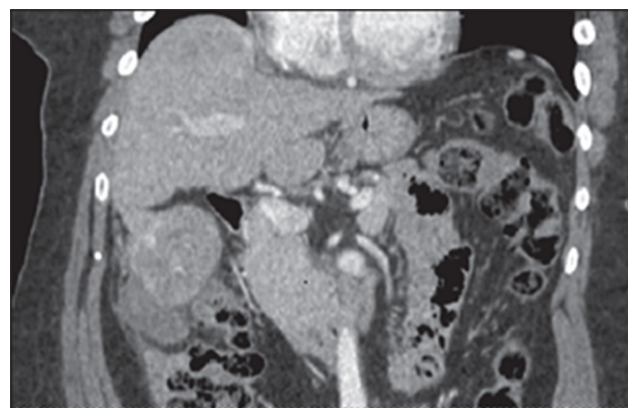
Computed tomography scan confirming evidence of hepatocellular cancer with regional hematoma
